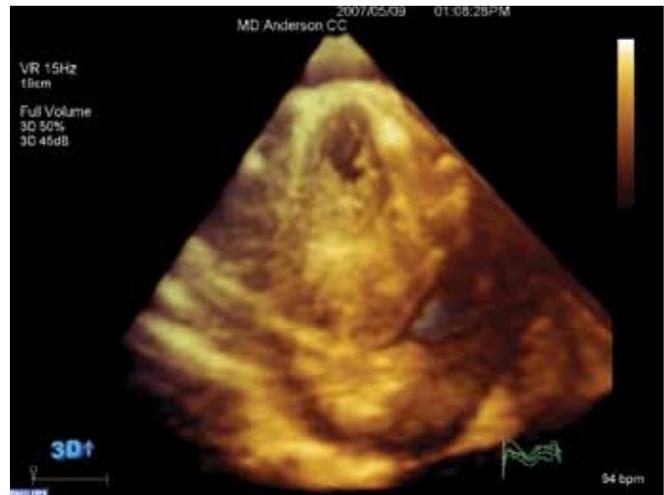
Cropping of a full-volume acquisition obtained from the apical 4-chamber view of the patient with primary cardiac sarcoma mentioned in Figure 2. The tumor originates from the inferior, inferolateral and anterolateral walls of the LV. A large pleural effusion is seen with large amounts of echodense material visualized floating in the space.
